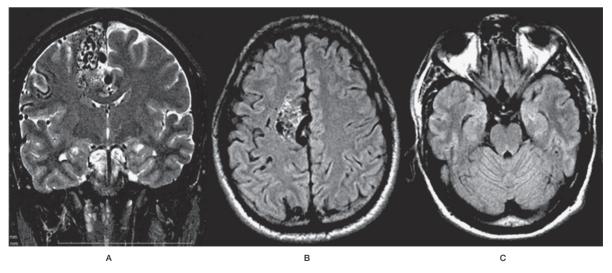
Cerebral magnetic resonance imaging: no radiological sign of intracranial hypertension and no lesion in optic pathways (A: frontal section; B,C: axial section).
